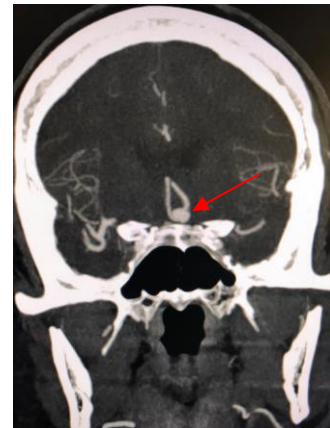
CTA of the brain showing bulbous appearance of an ACOMM aneurysm.
